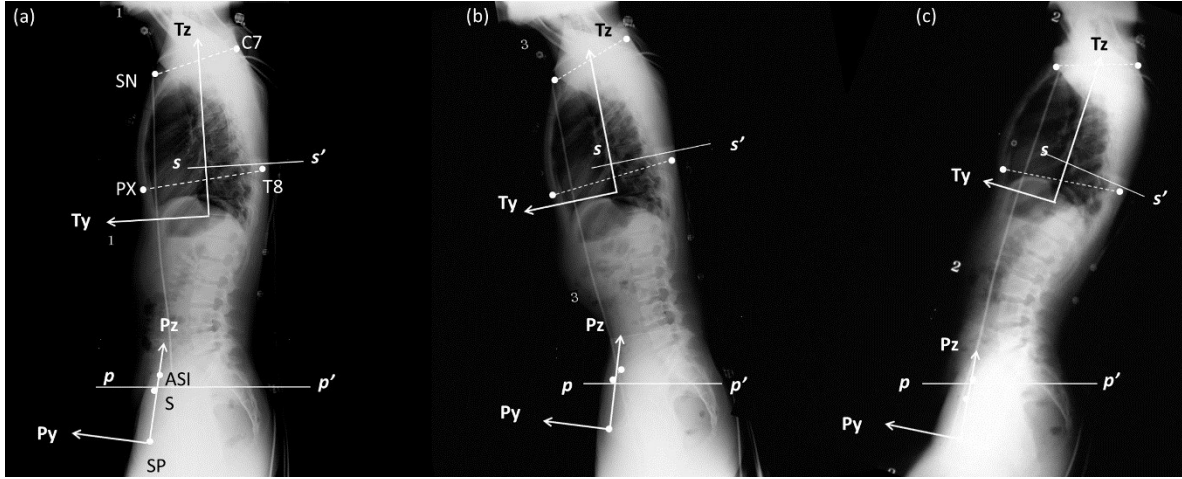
The X-ray photographs used for the validity test (from the viewpoint of fixed pelvis).
